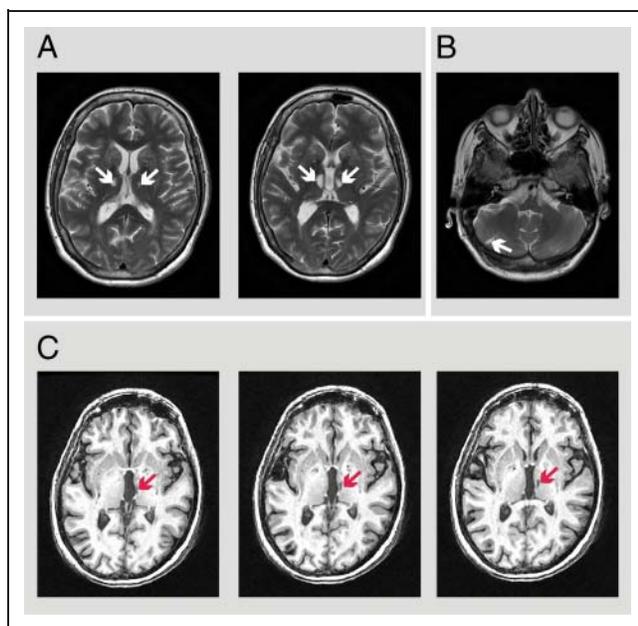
MRI sections of the patients. (A) Axial sections show bilateral lesions of the medial dorsal thalamus (marked by arrows) in T₂-weighted images of P01. (B) T₂-weighted section further reveals a small infarct in the left cerebellum of P01. (C) T₁-weighted axial sections of P02 show a right-sided lesion of the medial dorsal thalamus (marked by arrows). The left hemisphere is represented on the left side of the images.
